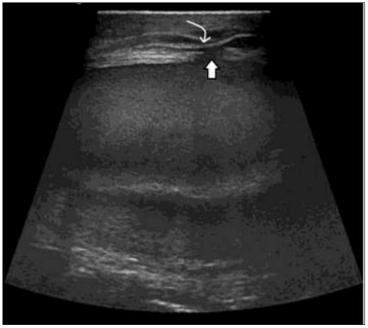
Ultrasound of the left scrotal sac performed with a linear probe reveals a hypoechoic fluid collection containing internal debris, producing a "falling snow" appearance. There is evidence of disruption in the tunica layers (indicated by solid white arrow), while the tunica vaginalis remains intact (indicated by the curved white arrow)
